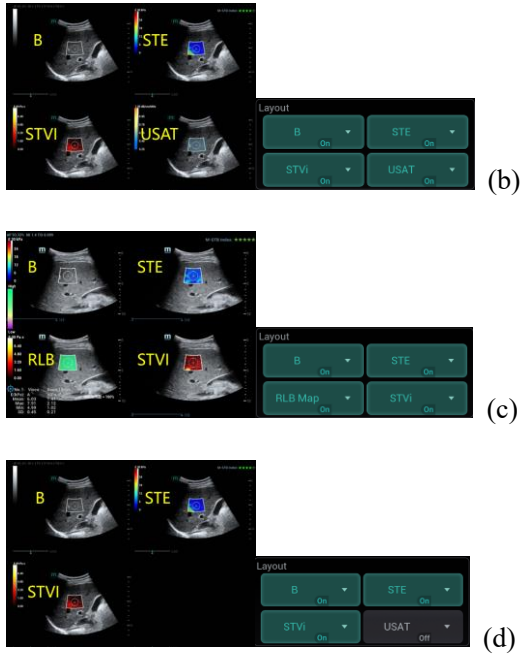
(a) Control panel interface of real-time multi-parametric ultrasound imaging and analysis tool; (b), (c), (d) Real-time imaging functions selected in Layout.
